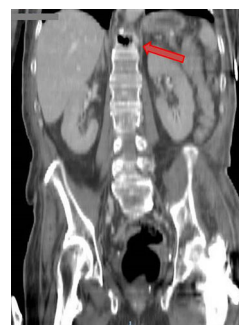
Sagittal CT scan of the abdomen.
